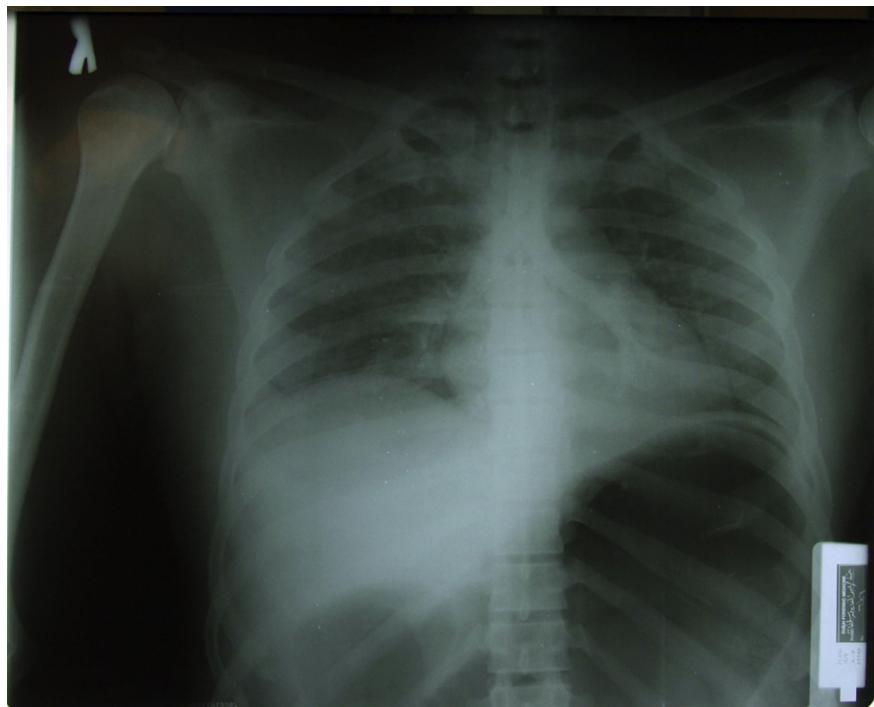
Chest X-ray showing radio-opacities along the area of the esophagus and air passages.
